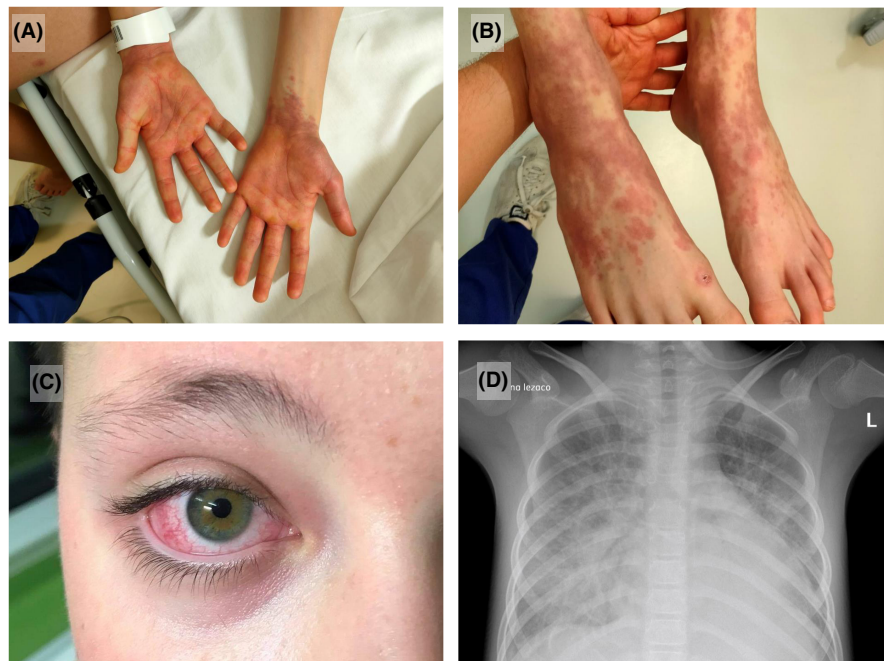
Clinical symptomatology in children with MIS-C. The pictures present the patients with MIS-C hospitalized in Pediatric Teaching Clinical Hospital of the Medical University of Warsaw, after informed consent was taken from the carer and the patient. (A, B) Typical cutaneous manifestations of MIS-C: generalized rash, dominating in extremities and acral regions. Palms and soles are involved demonstrating a polymorphic, maculopapular, and diffuse erythroderma with single “target lesions” typical for erythema multiforme. (C) Non-suppurative, limbic sparing conjunctivitis. (D) Chest radiograph of a 12-year-old girl with MIS-C demonstrates bilateral pulmonary consolidations and ground glass opacities with the predominance in the lower zone.
